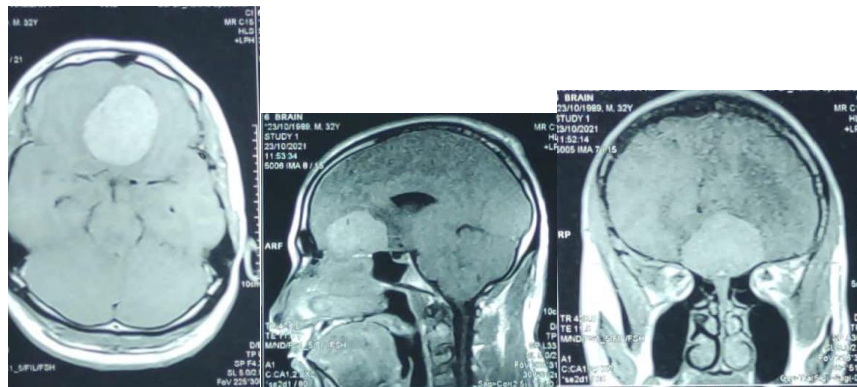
pre and post-operative MRI brain with the contrast of patient with olfactory groove meningioma demonstrate total excision of the lesion
